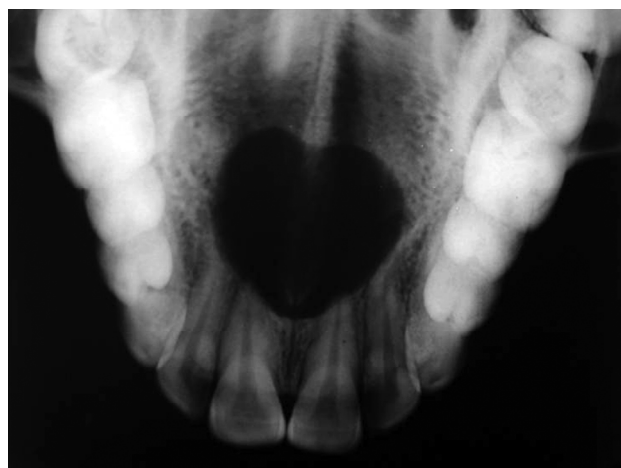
Radiographic picture of nasopalatine duct cyst showing radiolucent area in the palate
